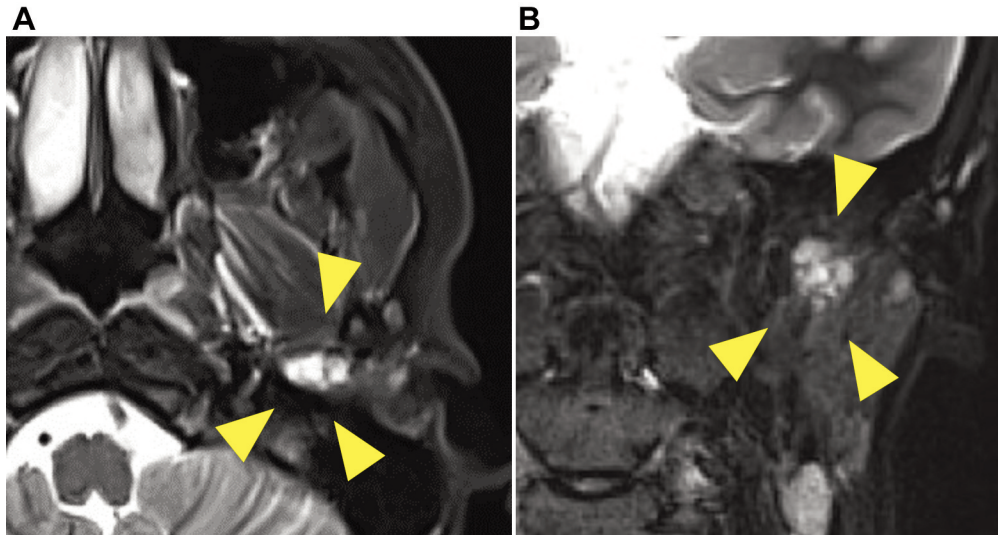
Contrast-enhanced magnetic resonance imaging of the parotid gland. (A) Axial; (B): coronal. A high-signal area with a maximum diameter of 10 mm on T2-weighted images is observed in the deep lobe of the left parotid gland, with a contrast effect at the margins (yellow arrow). The tumor extends into the parapharyngeal space.
